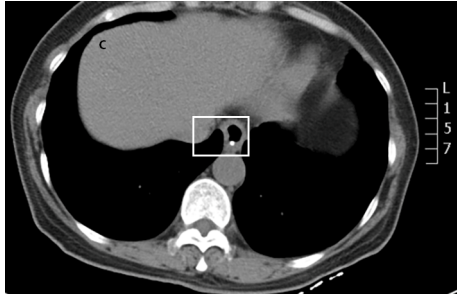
CT re-examination three months after tumor removal.
